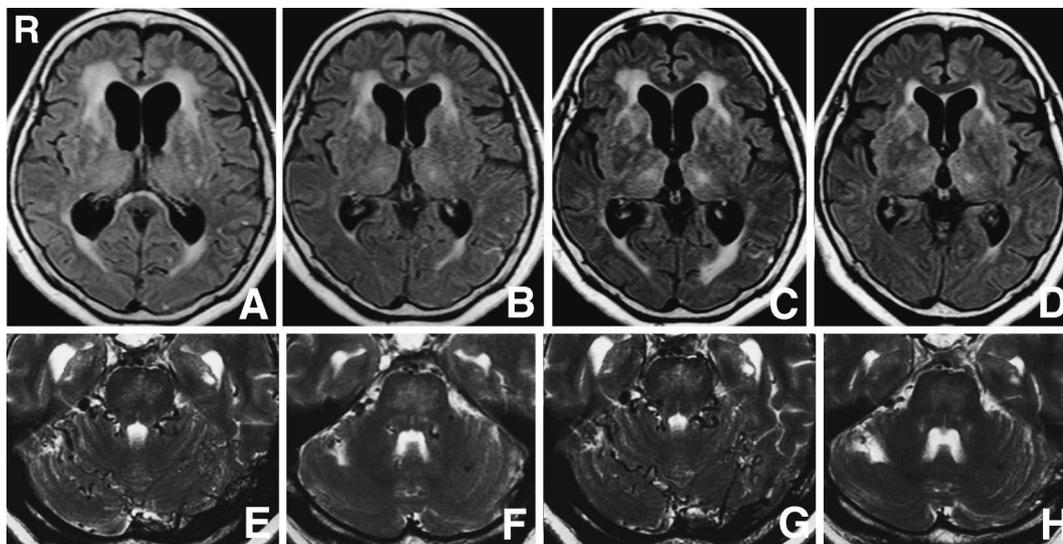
Axial fluid-attenuated inversion recovery (A-D) and T₂-weighted (E-H) magnetic resonance images. A, E: Dilation of the ventricular systems and periventricular hyperintensity area, and abnormal flow voids in the cerebellum bilaterally are shown before transarterial embolization. B, F: Ventricle size and hyperintensity of periventricular area are reduced after transarterial embolization. C, G: After recurrence of the symptoms of hydrocephalus, increased hyperintensity changes in the periventricular area and cortical venous reflux are seen. D, H: Diffuse hyperintensity changes in the white matter improved and the cortical veins disappeared after transvenous embolization.
